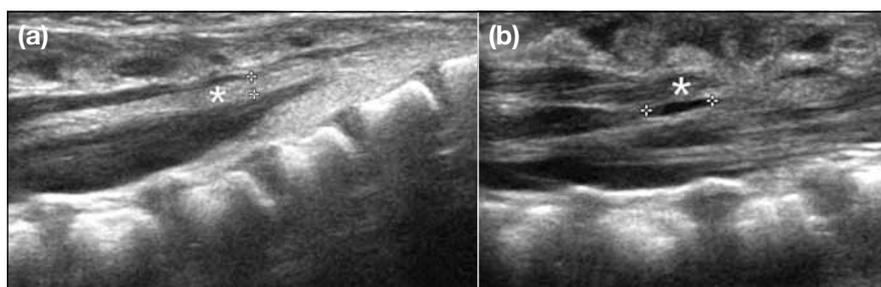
Longitudinal sonographic images of a neonatal spine show (a) prominent filum terminale (asterisk) measuring 1.6 mm thick, and (b) a small (5 mm) well-defined fusiform-shaped cystic lesion (asterisk) in the filum terminale, compatible with a small filar cyst. Note its midline location is just below the conus medullaris, which distinguishes it from other cystic intraspinal lesions.
